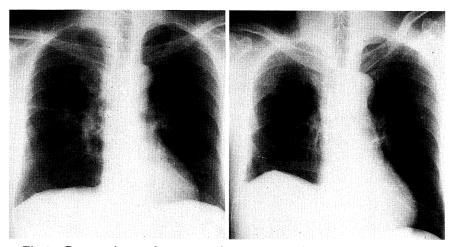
Preoperative and postoperative (3 years after sleeve right upper lobectomy) chest x-ray films of a 56-year-old man.
